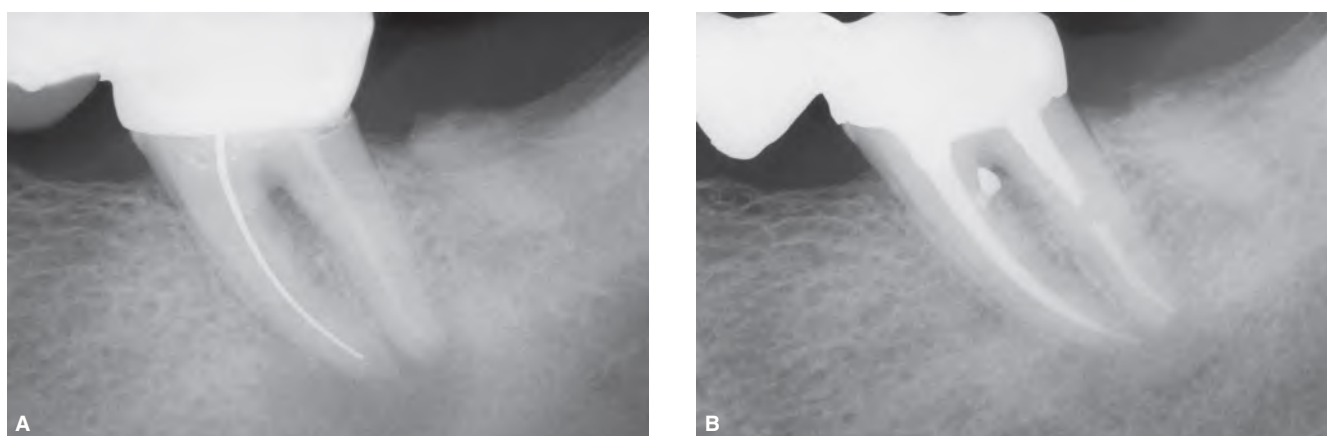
A. A radiograph of a mandibular left second molar reveals a poorly-fitting bridge, canals holding a silver point and paste, and evidence of furcal and apical pathoses. B. Ten-year recall radiograph shows the importance of three-dimensional endodontics and restorative excellence.
